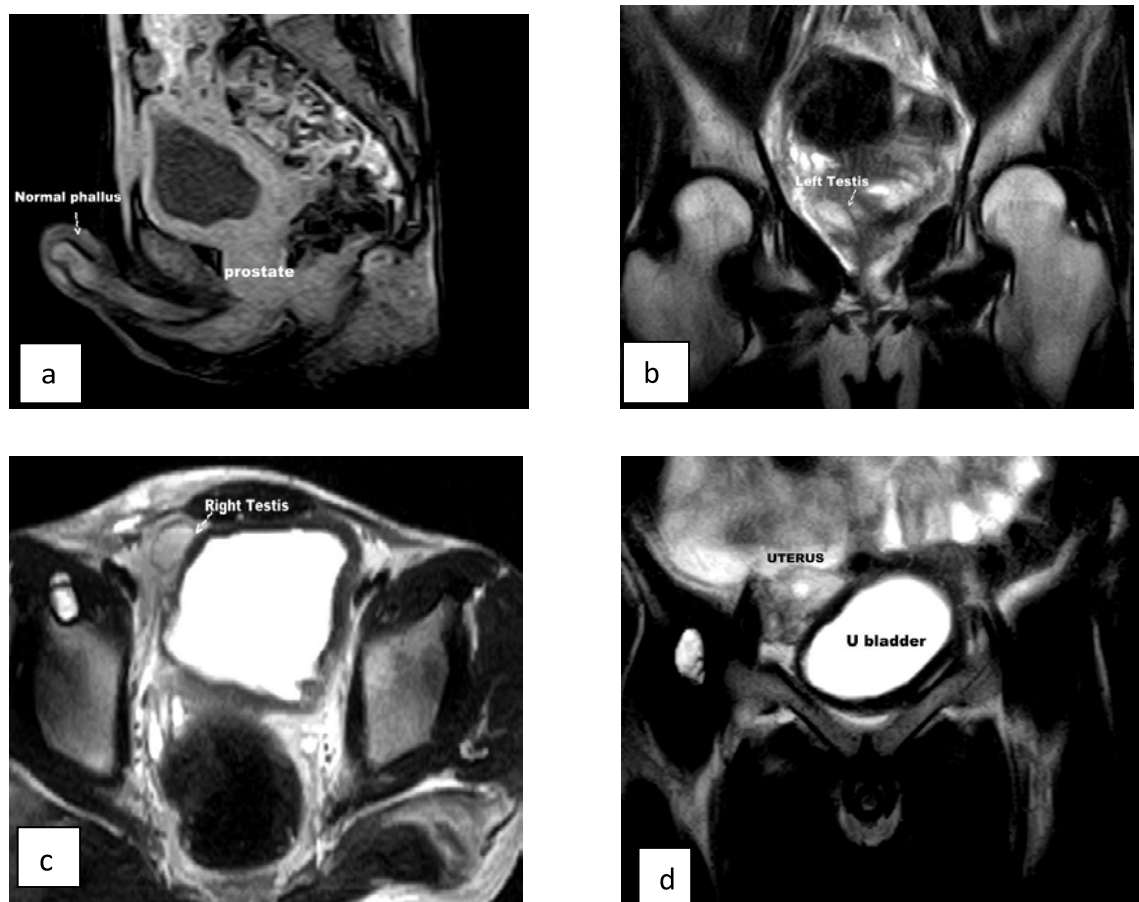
a) MRI Sag image showing prostate and phallus. b) Left testis near the right side of base of urinary bladder. c) MRI T2 WI axial image showing right-sided undescended testis located at the deep inguinal ring d) MRI T2 WI coronal image showing uterus above the urinary bladder.
